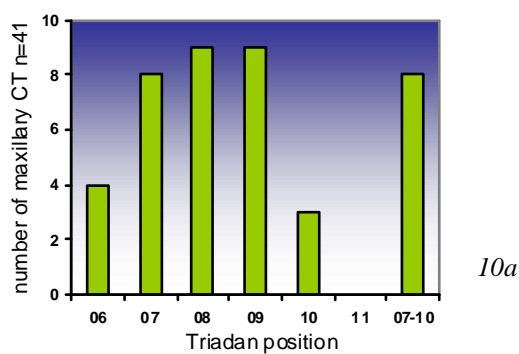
Triadan positions of a. maxillary (41/79 CT; 52%) and b. mandibular CT (38/79; 48%) with apical infections.
